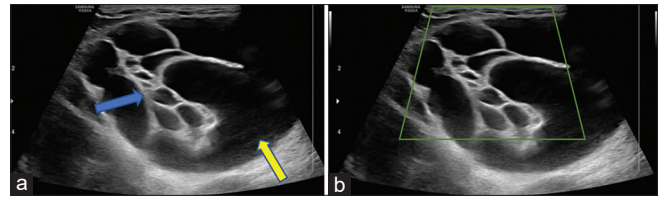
Ultrasound images showing (a) large cystic lesion (yellow arrow) in the inguinoscrotal region with multiple thick and smooth septae within it (blue arrow), (b) on color Doppler, it did not show vascularity suggesting dilated lymphatic channels
